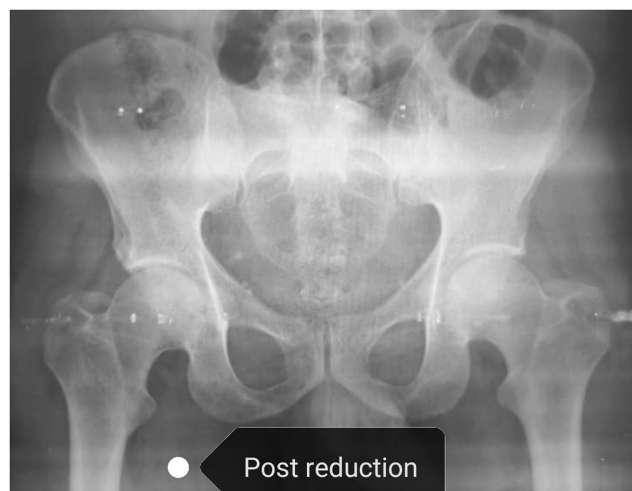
Pelvic radiograph after reduction confirmed concentric reduction in both hips.
